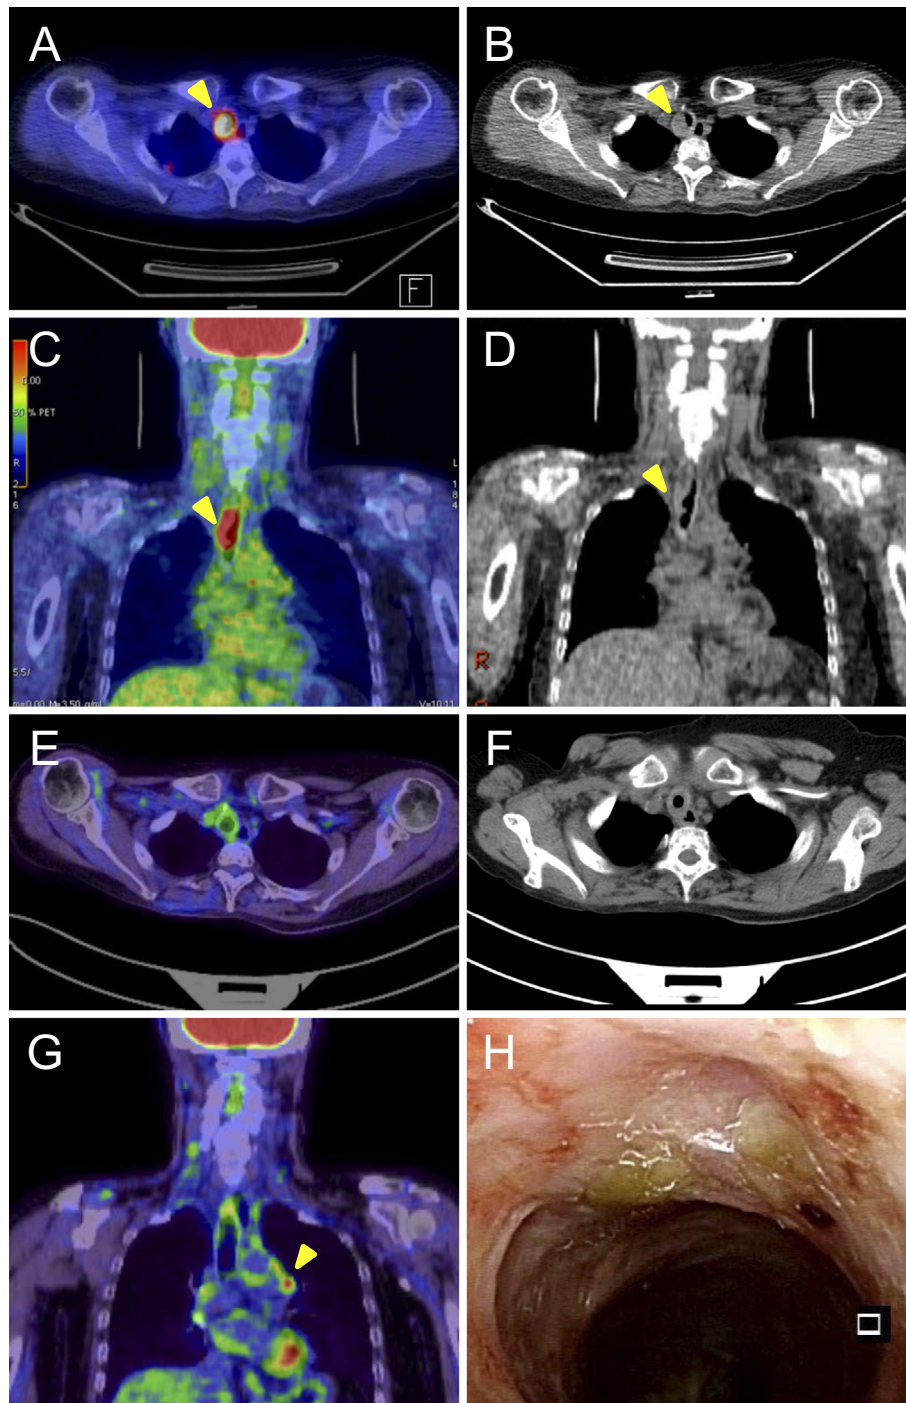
The positron emission tomography (PET) and chest computed tomography (CT) findings of the patients with tracheal neuroendocrine carcinoma. At the first admission, PET (A, C) and CT (B, D) showed a mass in the right side of the trachea. In September 2016, PET (E) and CT (F) showed a well-controlled tracheal mass, which was also confirmed by laryngoscope (H); however, PET showed fluoro-deoxyglucose (FDG)-avid striatum lymph node swelling (G).
